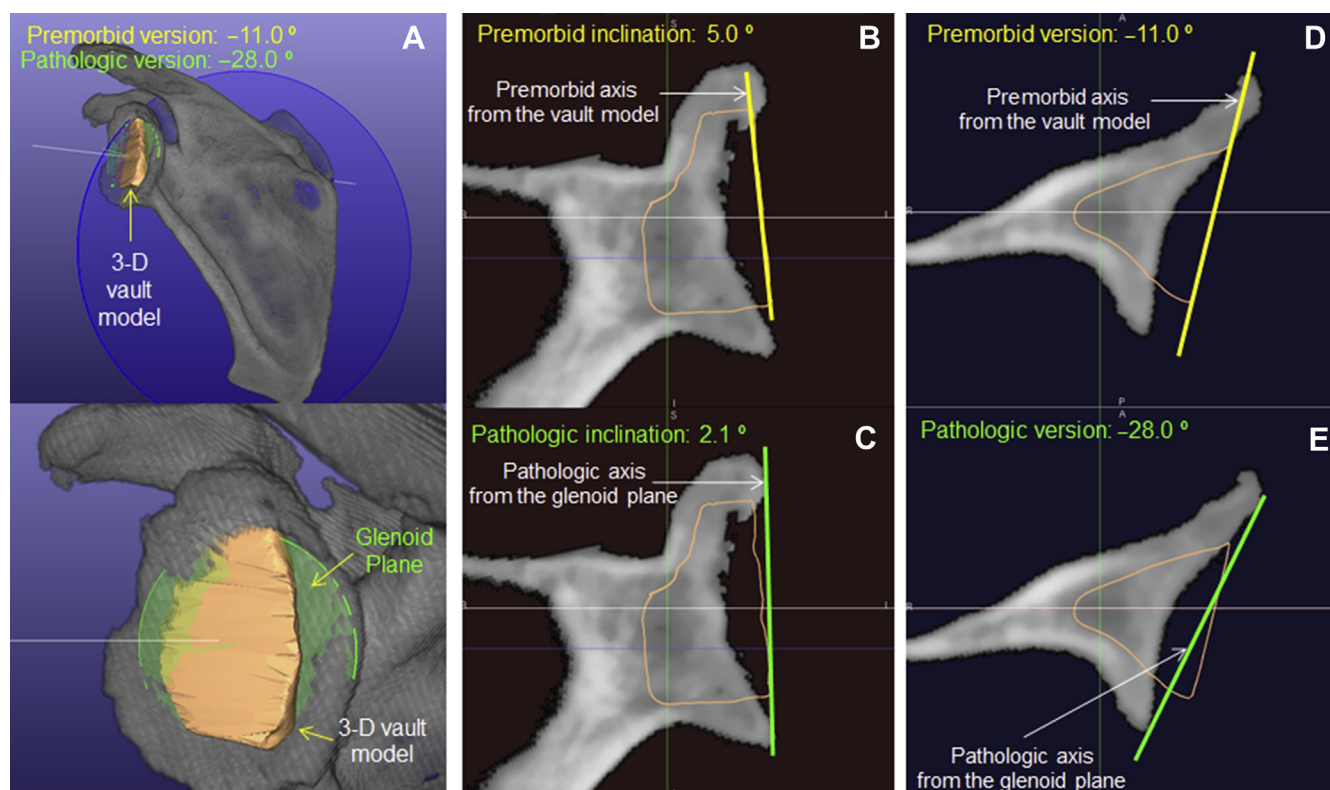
The glenoid vault model (A) is virtually placed into the glenoid of each preoperative CT scan as a tool to define premorbid glenoid anatomy. Premorbid (vault) glenoid version and inclination are measured in 3D from the scapula plane and the plane of the glenoid vault surface. (B-E) Representative 2D orthogonal views relative to the scapular plane are used to confirm vault model position and demonstrate pathologic and premorbid (vault) inclination (B, C) and version (D, E). Joint line medialization of the pathologic glenoid surface relative to the vault model surface can also be assessed on the 2D orthogonal views. Reproduced from Iannotti et al.¹⁰
